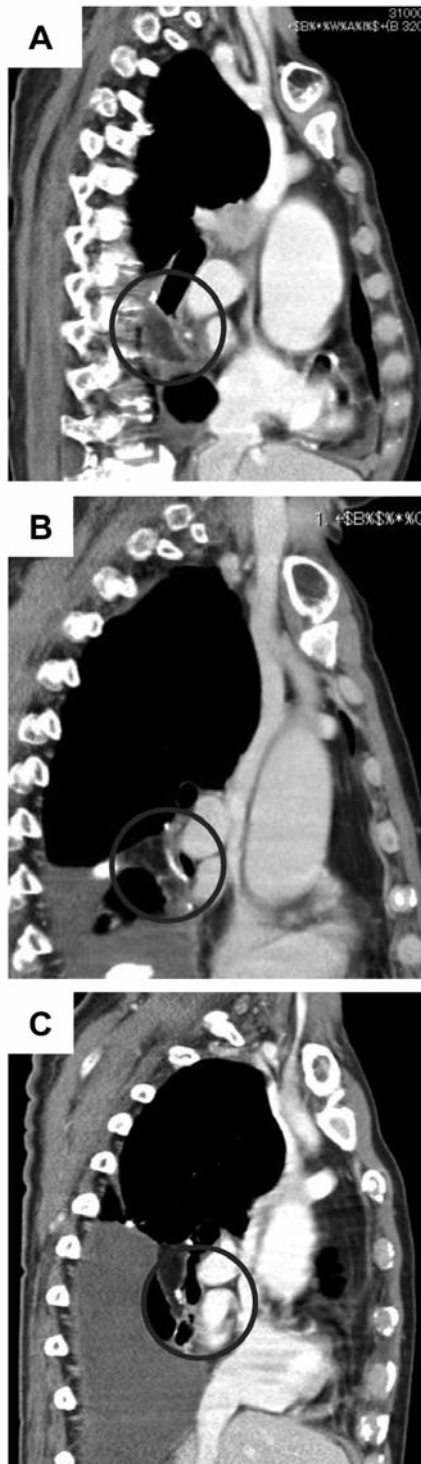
A: Chest computed tomography (CT) of Case 2, showing residual pedicle pericardial fat tissue (PFT) (black circle) around the bronchial stump in the right thoracic cavity (time from surgery until CT: 639 days). B: Chest CT of Case 9, showing residual isolated PFT around the bronchial stump (183 days). C: Chest CT of Case 27 in case in which the Yatsuhashi method was applied, showing residual isolated PFT (108 days).
